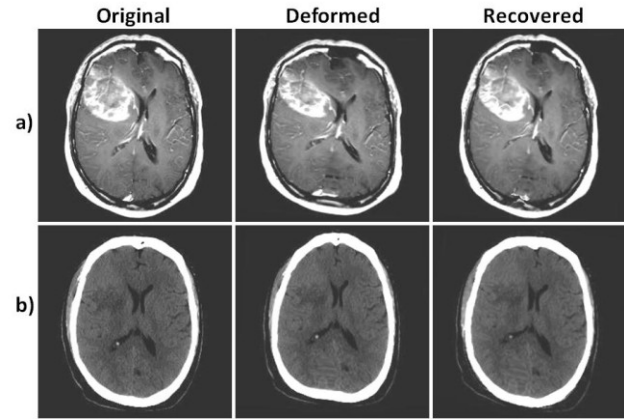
a) MRI images, b) CT images.
